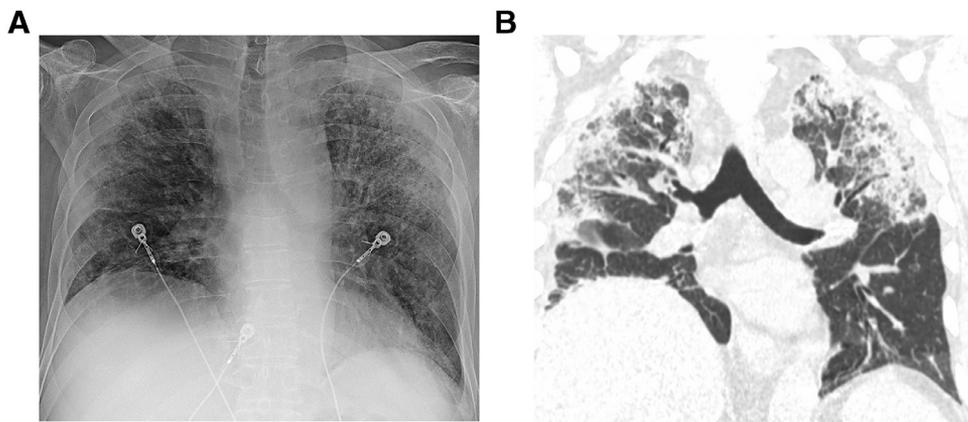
A 75-year-old male with rheumatoid arthritis and shortness of breath from organizing pneumonia. (A) Frontal radiograph shows upper lung predominant peripheral consolidation. (B) Coronal reformatted HRCT image shows identical findings. The differential diagnosis includes chronic eosinophilic pneumonia. Pleuropulmonary fibroelastosis could be considered if more upper lobe volume loss were present.
